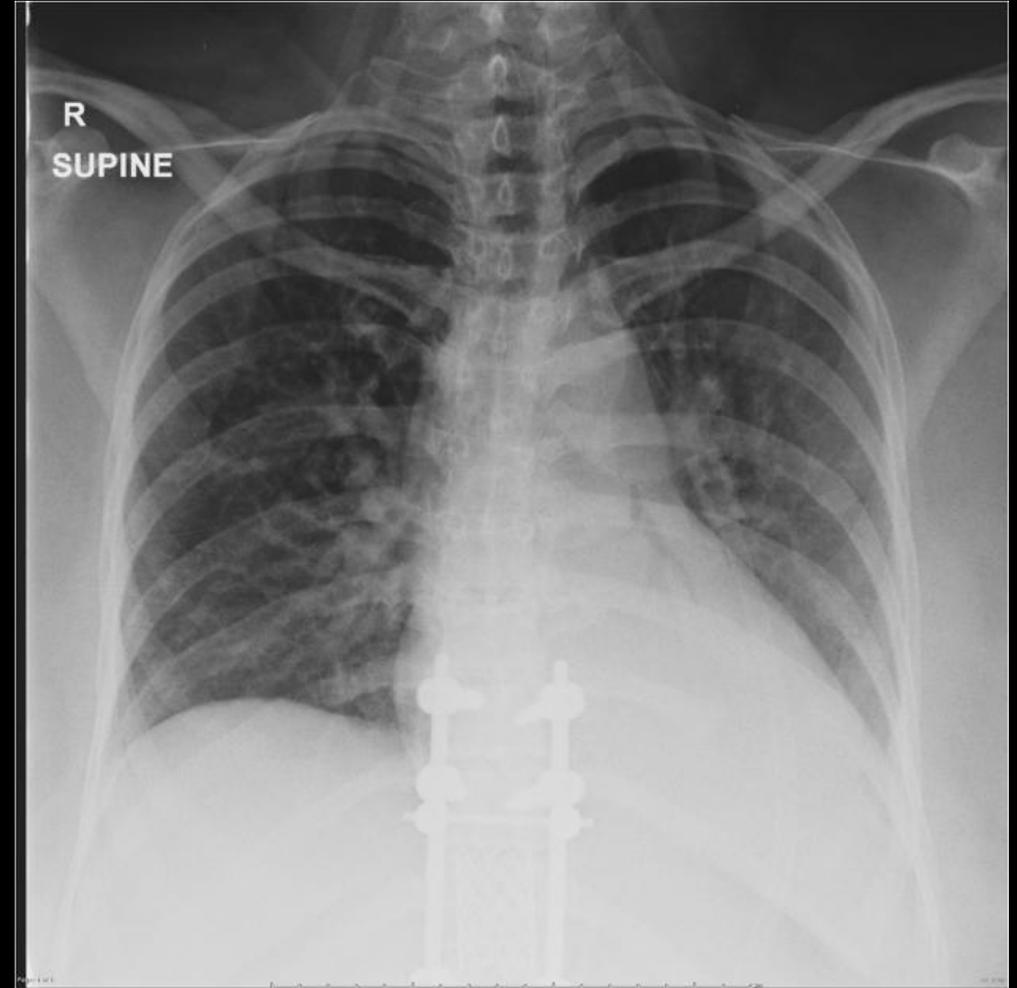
Chest radiograph obtained six hours after the initial
